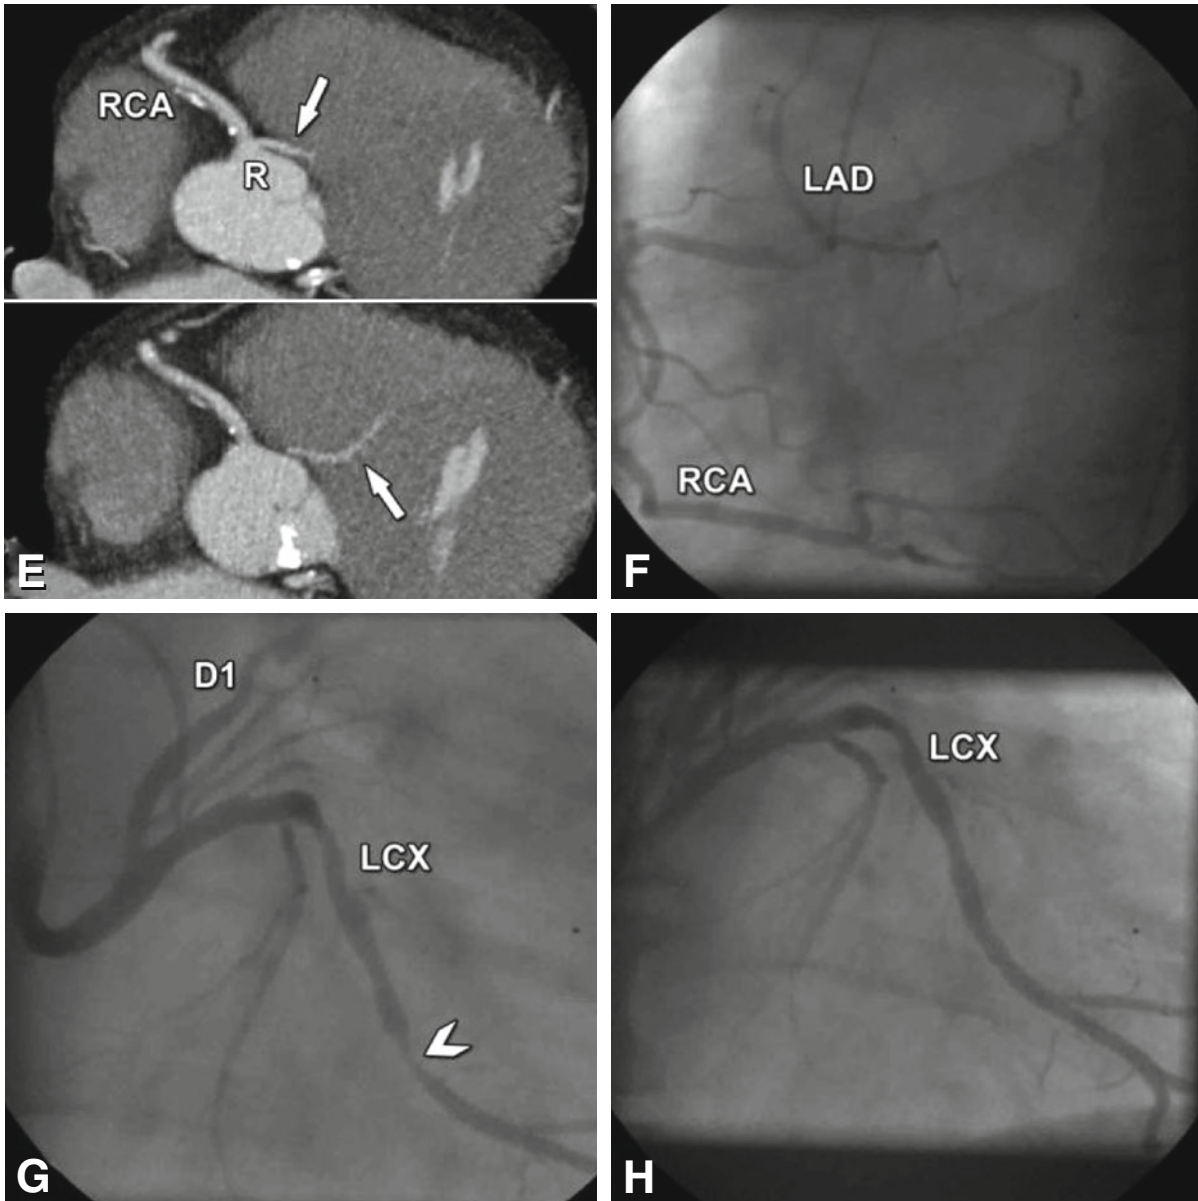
Complex though benign coronary anomaly with two coronary ostia from the right sinus of Valsalva (R) and no coronary ostium on the left sinus of Valsalva (L). There are two separate vessels supplying the anterior segments of the myocardium, which were assumed to be the left anterior descending coronary artery (LAD) and first diagonal branch (D1, Panels A–C) based on their location (split LAD). The D1 and the left circumflex coronary artery (LCX) arise with a common trunk from the right sinus of Valsalva (R), which passes retroaortically between the aorta and the right atrium (RA) and the left atrium (LA) (asterisk in Panel D). This common trunk then splits into the D1 and LCX, which then pass to the anterolateral myocardium and the left atrioventricular sulcus, respectively. The right coronary artery (RCA) and the LAD arise from a common ostium also from the right sinus of Valsalva (Panels C and D). The RCA takes the typical course, whereas the LAD takes a prepulmonary course to the anterior interventricular sulcus. Coronary CT angiography of this 64-year-old male patient with known severe coronary artery disease was done after conventional coronary angiography for further imaging of the courses of the anomalous vessels. The patient then received two stents into the LCX due to high grade stenosis. Panels A and B show three-dimensional volume renderings of the heart from two different viewing angles, which do not allow full identification of the coronary anatomy. The three-dimensional reconstruction of the coronary tree in Panel C also fails to clearly show the course of the coronary arteries. The most distinct anatomical depiction is given by the globe view in Panel D, which resolves the origins and courses of the anomalous coronary arteries.
